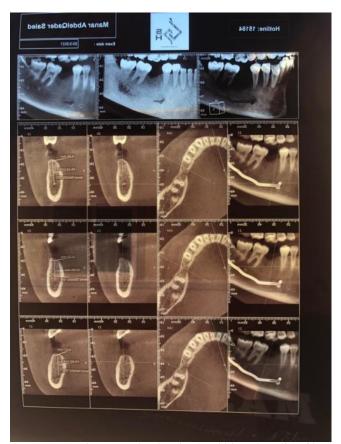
cone beam CT showing depth, width and quality of bone.
